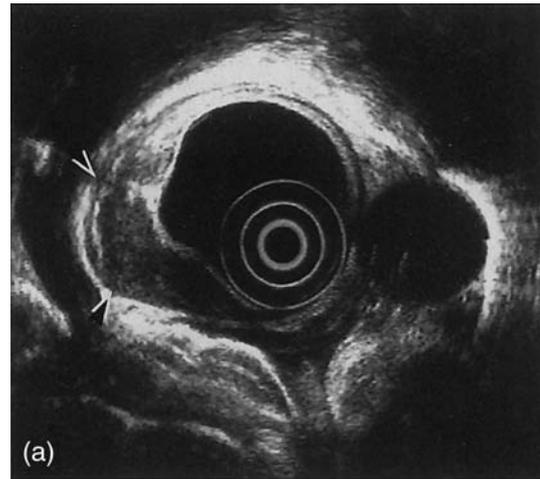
A T2 esophageal carcinoma. (a) A T2 tumor as seen by endoscopic ultrasound. The hypoechoic (black) tumor invades the hypoechoic (black) fourth ultrasound layer (muscularis propria) but does not breach the boundary between the fourth and fifth ultrasound layers (arrows). (b) A T2 tumor invades but does not breach the muscularis propria. From reference 20, with permission.
